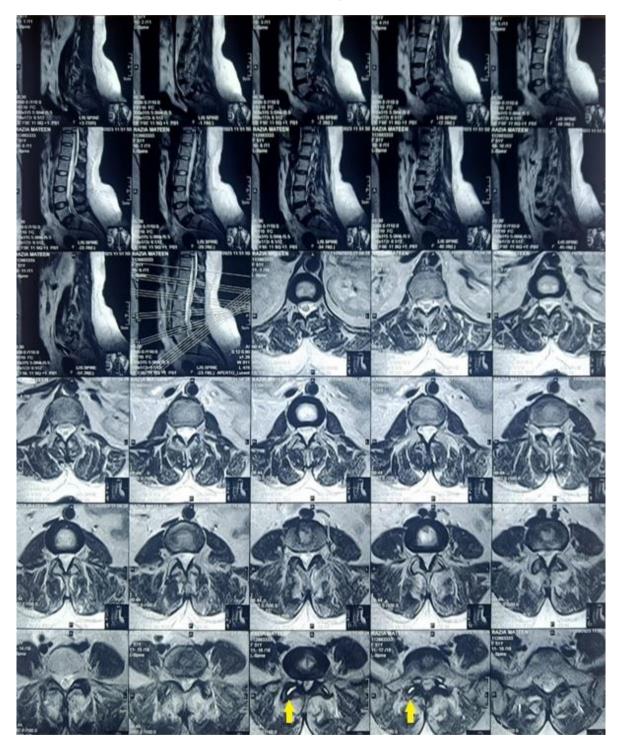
MRI Lumbosacral Spine T2- weighted image of the patient showing presence of significant fluid in facet joints at L5-S1 level on axial cuts with abnormal facet fluid marked with yellow arrows but no abnormality in alignment at L5-S1 level on supine sagittal view of MRI
